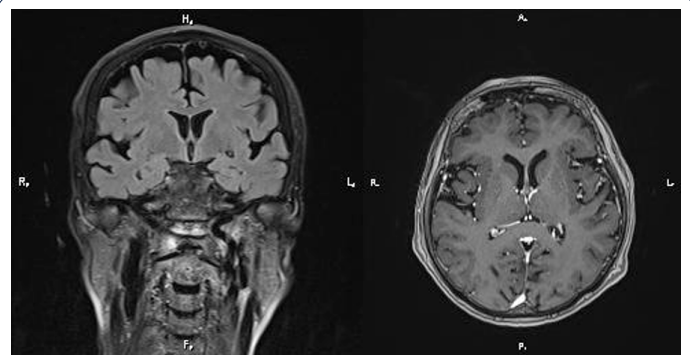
Brain MRI performed 48 hours dupa instalarea simptomelor with no pathological findings.
